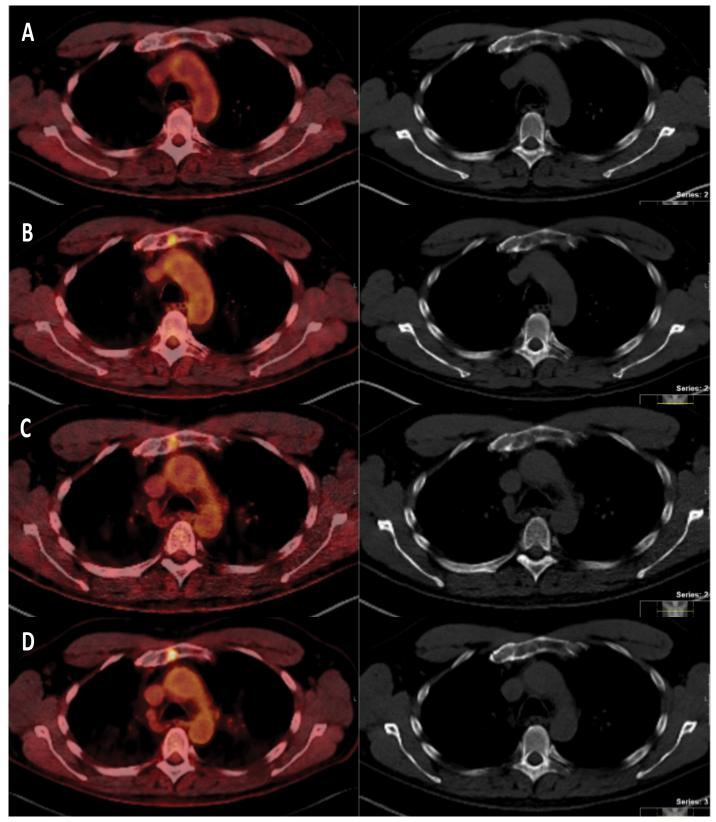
Baseline image (PET/CT) (A) and FUs 3, 6 and 15 months after SBRT respectively (B, C and D).
